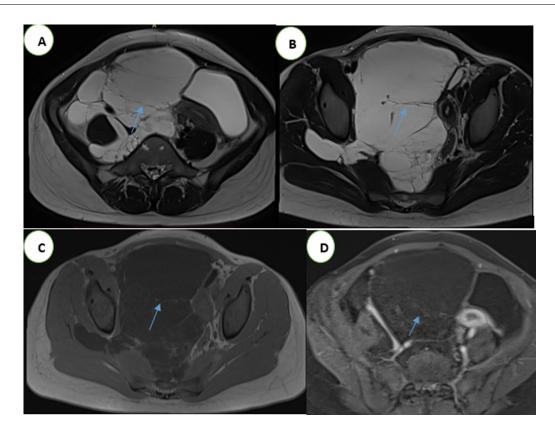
Abdominal and pelvic MRI in axial sections, T2 sequence without FATSAT (A, B), T1 without FATSAT (C) and T1 FATSAT with Gadolinium administration (D) shows a voluminous cystic mass with fluid signal and fine septa (blue arrow).
